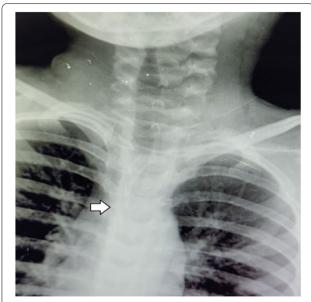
Xray soft tissue neck-AP view arrow showing part of tracheostomy tube
